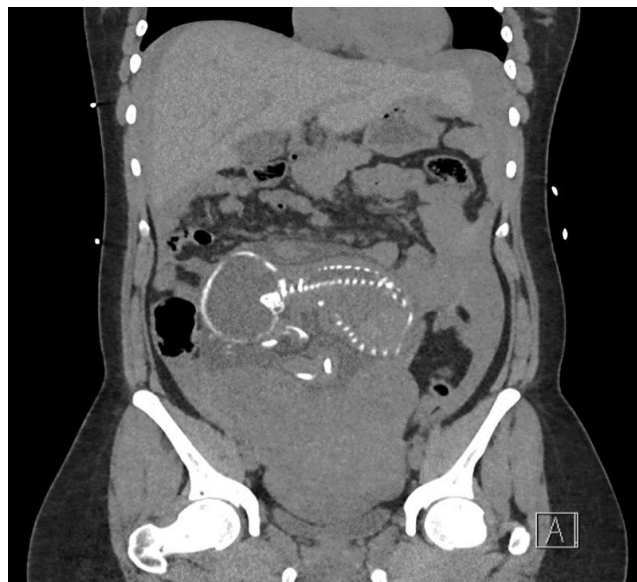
Coronal-view CT scan.
